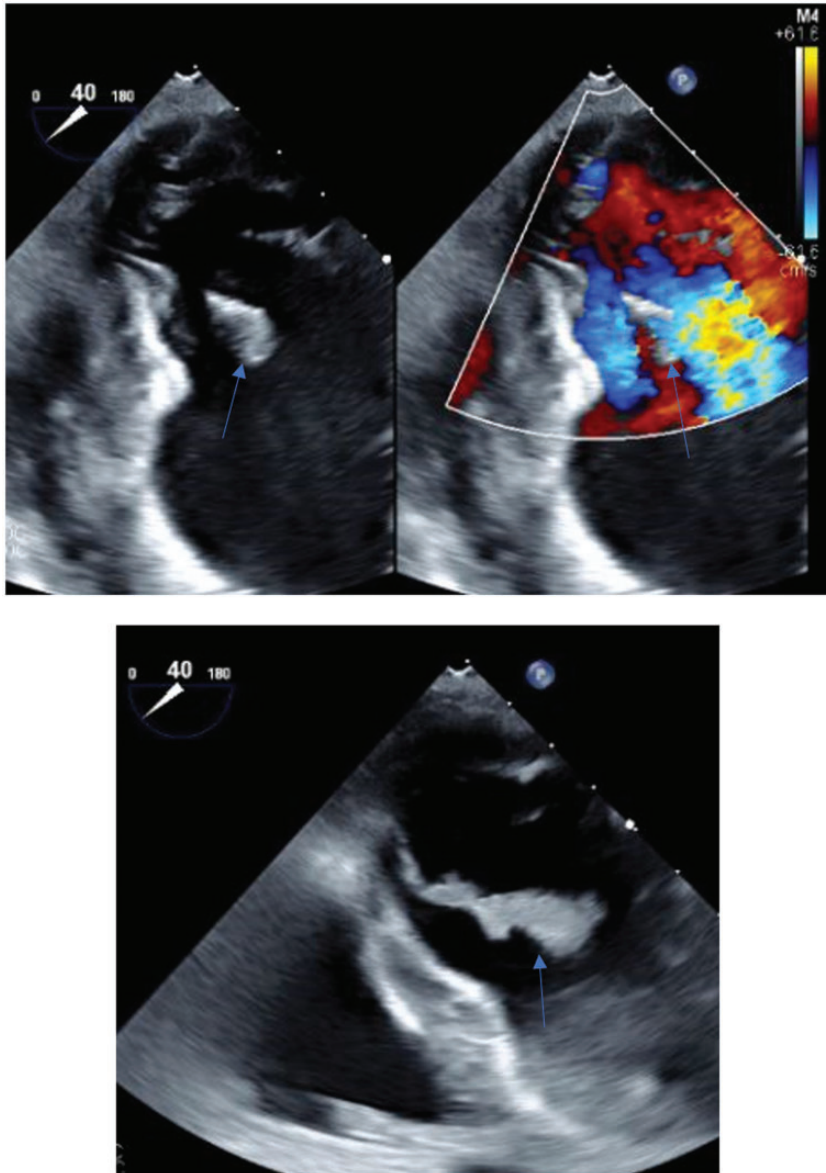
(Top left) Transesophageal echocardiography showing the mobile vegetation on the mitral valve (blue arrow). (Top right) Doppler ultrasound of blood flow through the mitral valve. (Bottom) Another view of the vegetation on the mitral valve (blue arrow).
